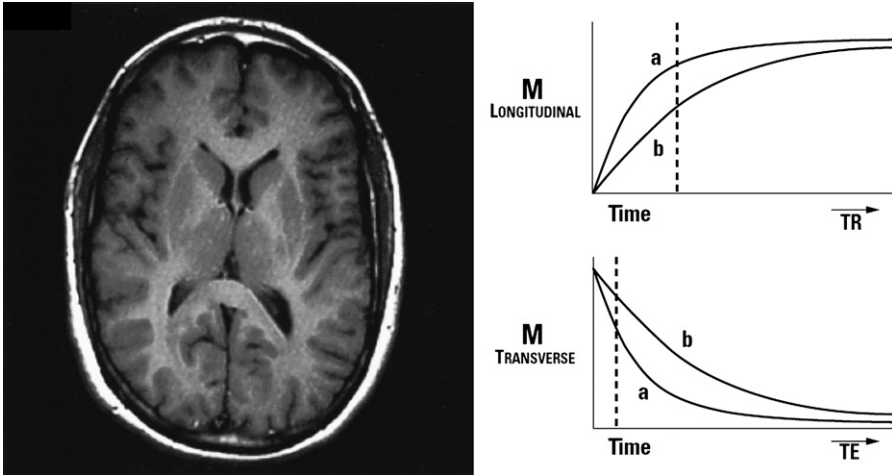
T1-weighted image acquired using adequate TR and short TE. (Courtesy of GE Healthcare, São Paulo, Brazil.)
